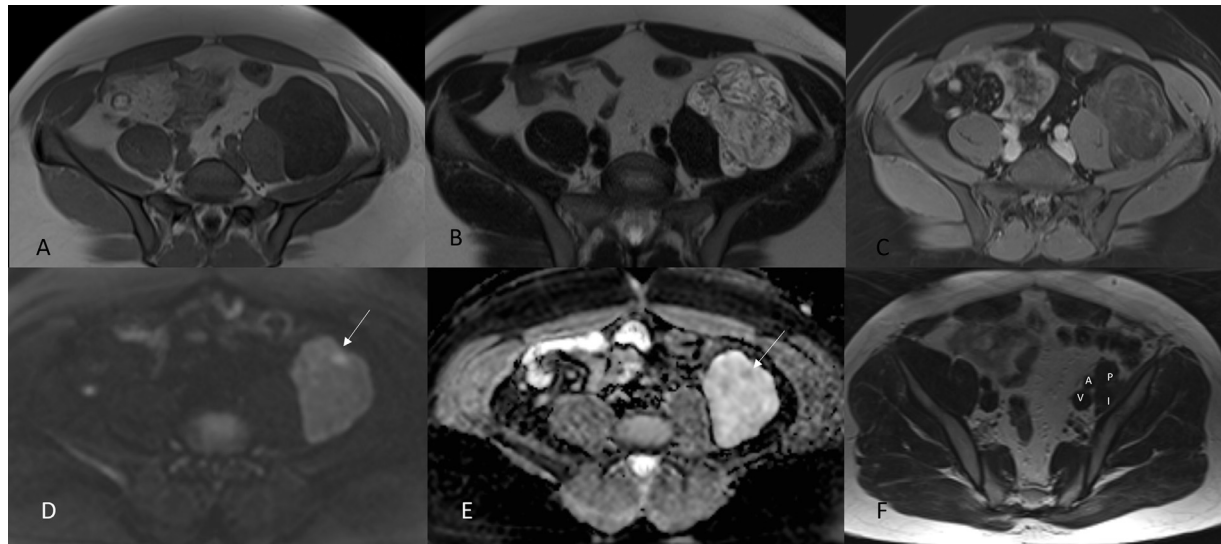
MRI imaging clarified morphological tumor characteristics depicting multiple intratumorous septa (B) with mild contrast enhancement (C), and fluid or slightly cellular matrix among septa. Few nodular septa thickenings with mild diffusion restriction and mild contrast enhancement (D and E) were also seen. A 12-month-follow-up MRI showed no residual or recurrent disease (F; A- external iliac artery; V- external iliac vein; P- psoas muscle; I- iliac muscle). 4A. T1 axial non-enhanced. 4B. T2 axial 4C. T1 fs axial contrast enhanced. 4D. DWI, b800 4E. ADC map. 4F. T2 axial (12-month-follow-up).
